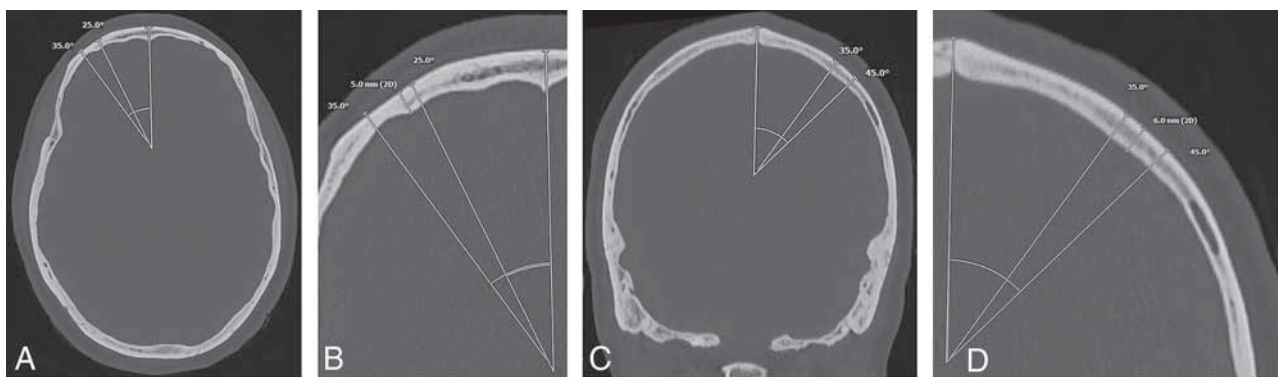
Example of calvarial thickness measurements obtained in the same patient in the axial and coronal planes. Full-field (A) and zoomed (B) axial bone kernel and bone window CT images demonstrate a sample axial thickness measurement obtained 25°–35° off midline. Full-field (C) and zoomed (D) coronal bone kernel and bone window CT images demonstrate a sample coronal thickness measurement obtained 35°–45° off midline.
